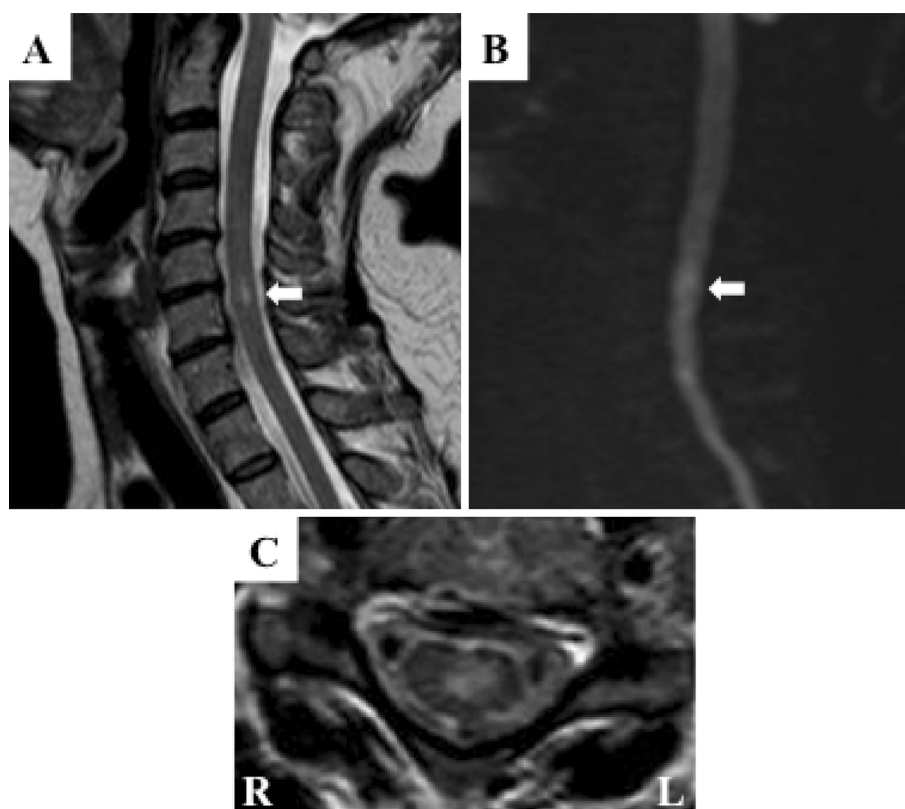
Magnetic resonance imaging (MRI) of the cervical cord. Sagittal T2-weighted image 14 days after the clinical onset showed intramedullary hyperintensity at the C5-C6 vertebral level (arrow) (A). Axial T2-weighted imaging at the C6 vertebral level showed intramedullary asymmetric hyperintensity, mainly located in the gray matter and sparing the peripheral part of the spinal cord. The involved area corresponded to the anterior spinal artery (ASA) territory (C). The lesion identified in the panel A showed hyperintensity (arrow) on diffusion-weighted imaging at 15 days after the clinical onset, a finding compatible with acute spinal cord infarction (B).
